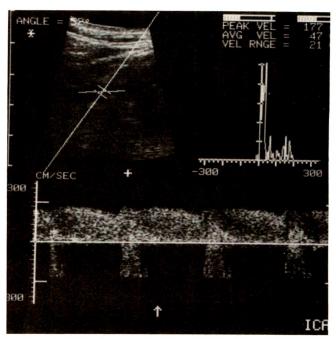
Duplex sonogram of internal carotid artery (ICA) just distal to severe (80-99%) stenosis shows considerable aliasing with summated peak velocity (including aliased portion) of 395 cm/sec. Note maximal velocity at end diastole is approximately 180 cm/sec, and spectral broadening indicates considerable turbulence.
